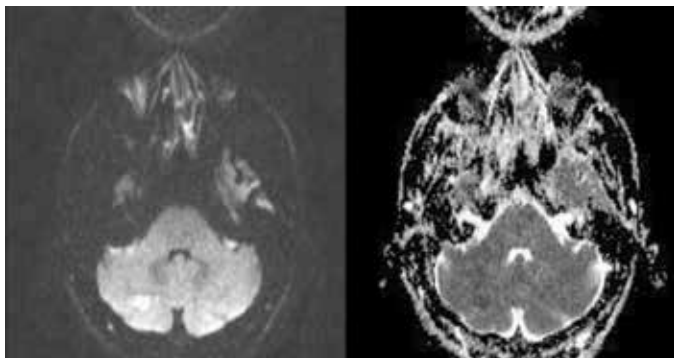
Diffusion obstruction compatible with acute infarction in the right cerebellar hemisphere seen in the cranial diffusion-weighted MRI of the first case
